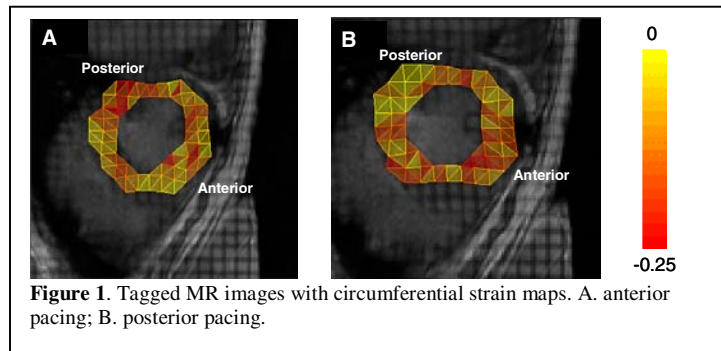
Tagged MR images with circumferential strain maps. A. anterior pacing; B. posterior pacing.
